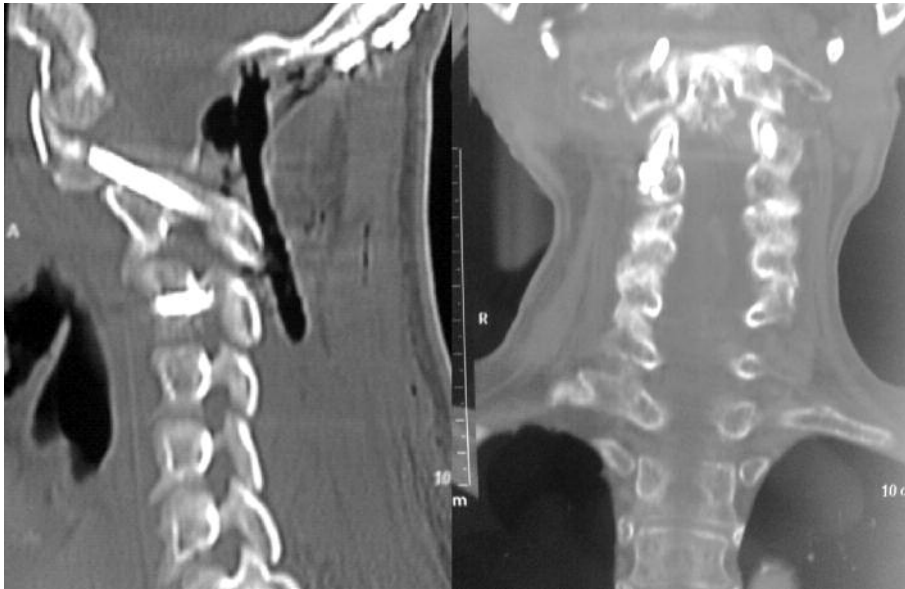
(a) A sagittal CT scan showed optimal transarticular fixation of the C1-C2 complex. (b) Coronal CT scan showed optimal transarticular fixation of the C1-C2 complex .
